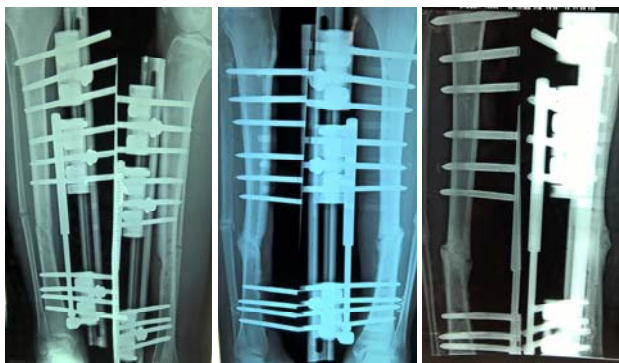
= Immediate post-op, and follow up xrays of orthofix.
